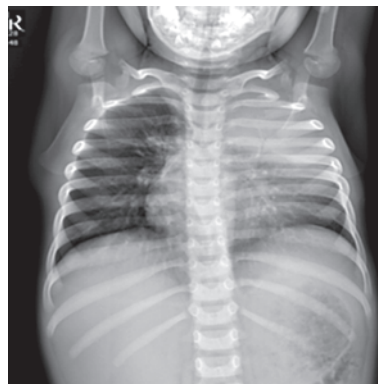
X-ray chest: Left upper lobe consolidation. Lingular involvement silhouettes the left cardiac border
